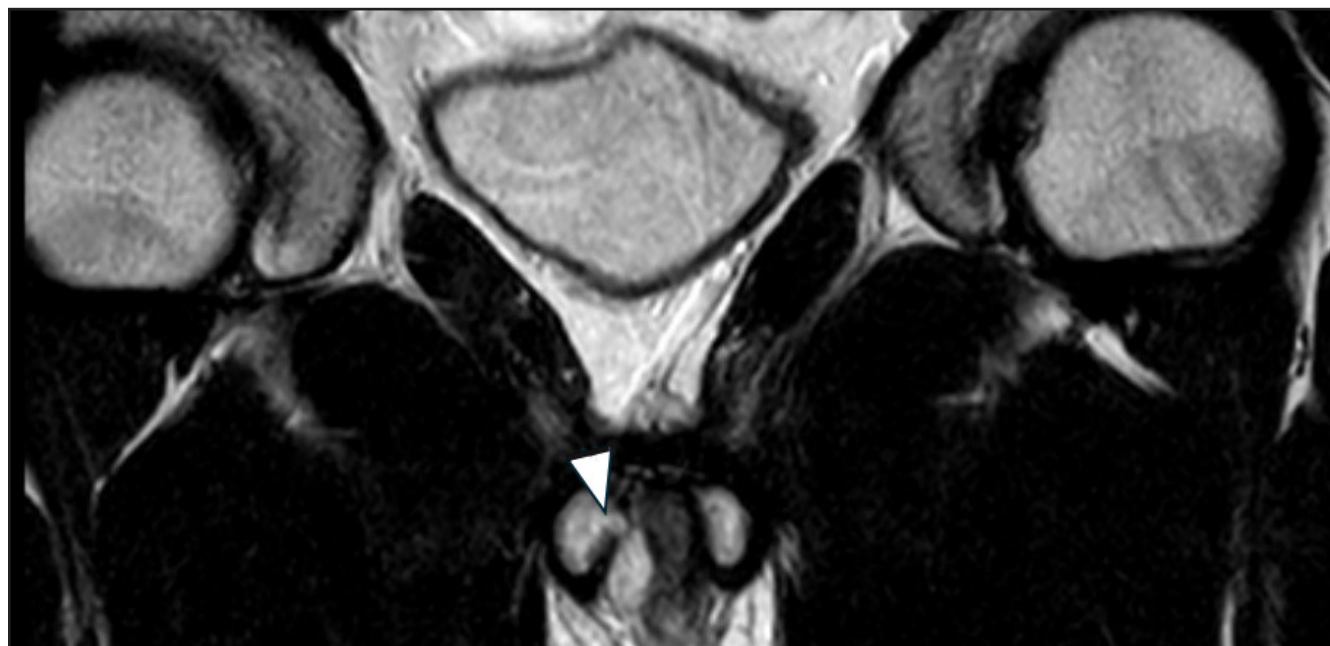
Coronal T2 weighted MRI image of the penis shows a small defect in the tunica albuginea of the right corpus cavernosum at 2 o'clock position near the base of the penis (white arrowhead). Please note the loss of continuity of the tunica albuginea.
